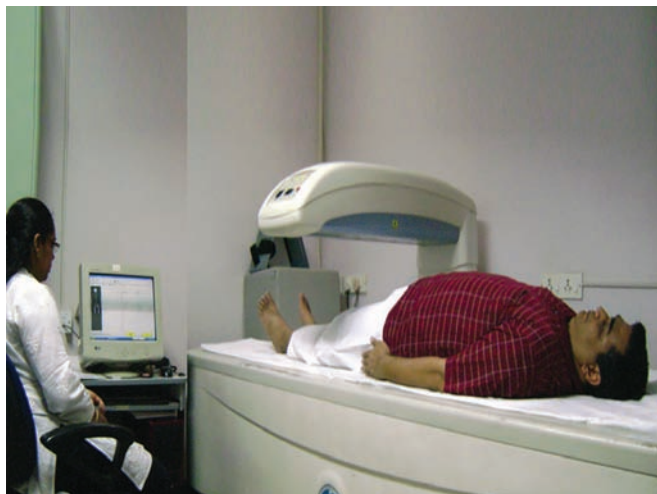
Measurement of fat mass by dual-energy X-ray absorptiometry (lunar prodigy, DPX-IQ and general electric healthcare)
